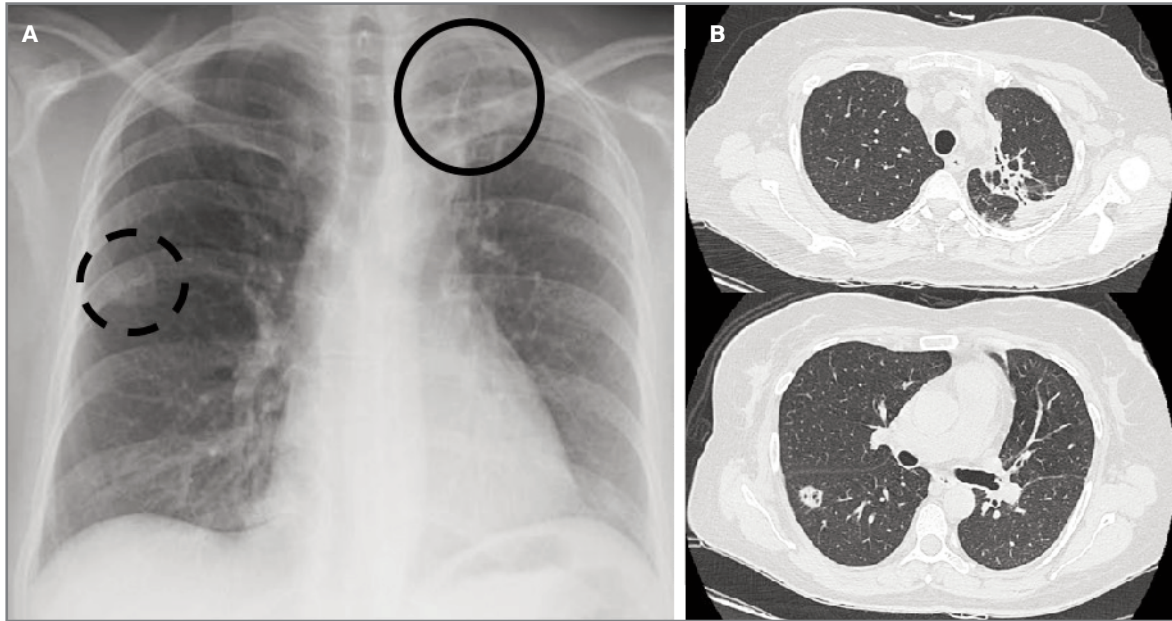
Chest X-ray (A) showing an heterogeneous hypotransparency at left apex (continuous line) and a peripheral right pulmonary nodule (dashed line) and corresponding computed tomography (B) with a retractile consolidation on the left upper lobe and lung nodule on the right upper lobe
